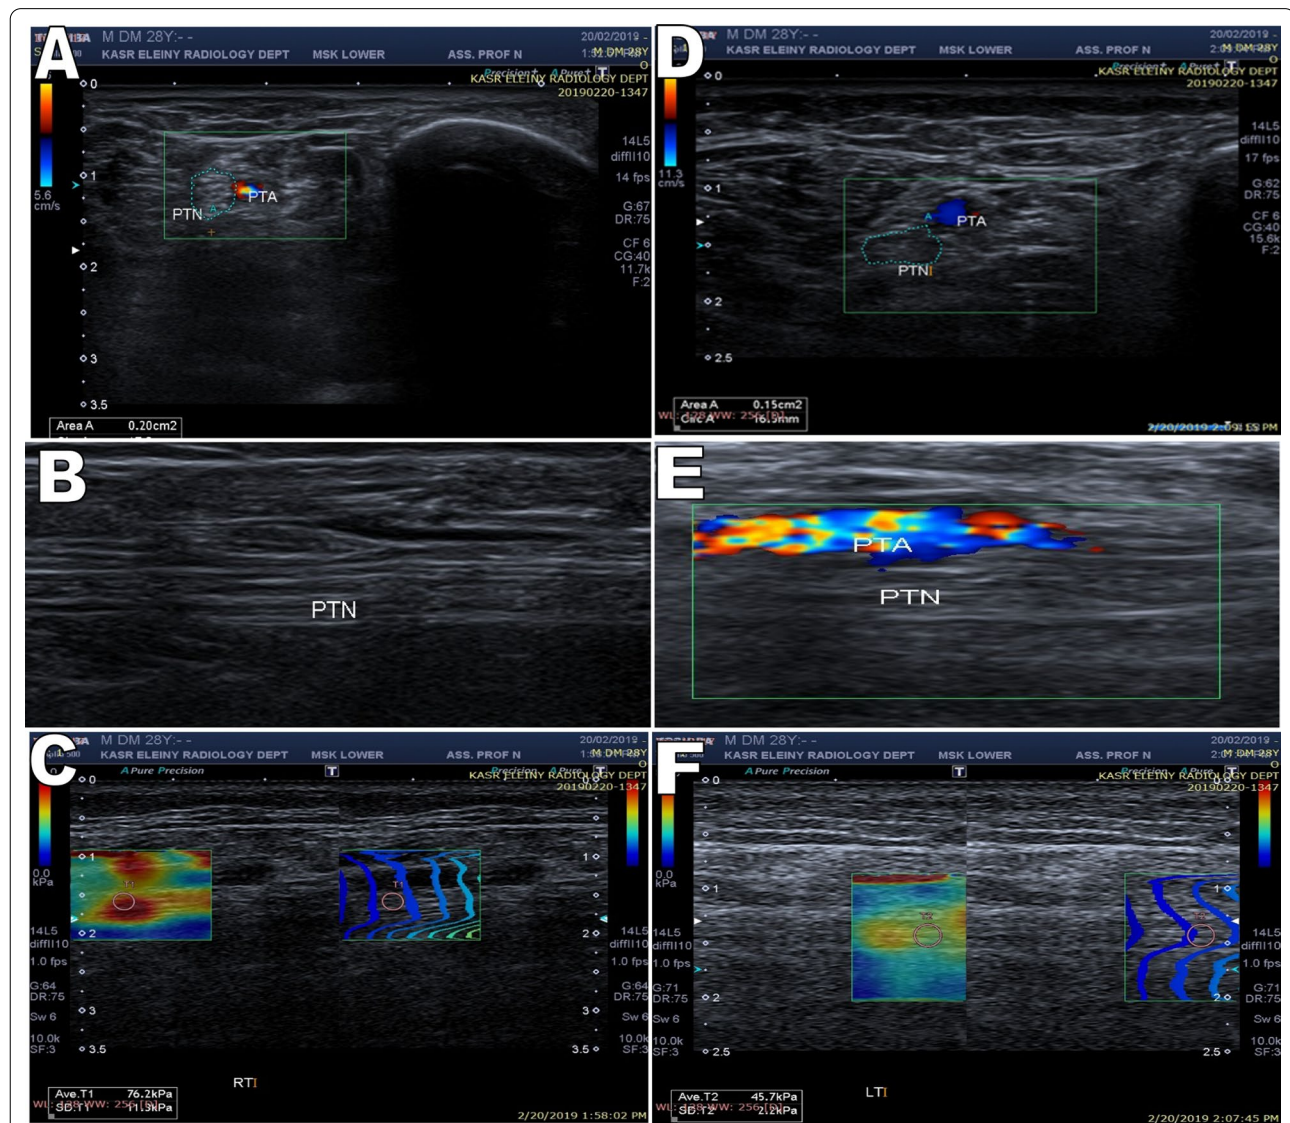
A 63-year-old male patient diabetic for 28 years on insulin treatment with uncontrolled blood sugar and elevated Hb A1c, presented with bilateral lower limb numbness, tingling, and burning sensation as well as axonal neuropathy on nerve conduction study. High-resolution ultrasound A shows the right PTN in relation to the PTA with its CSA measuring 20 mm². B B-mode image shows the longitudinal axis of the right PTN. C The right image is the B-mode, and the left image measures the elasticity of the PTN (76.2 kPa) with a color-coded box, circular ROI (T1) for quantitative measurements and a color code scale at the top side of the image. D demonstrates the left PTN in relation to the PTA with its CSA measuring 15 mm². E B-mode image shows the longitudinal axis of the left PTN. F The elasticity of the PTN (45.7 kPa) with a color-coded box, circular ROI (T2) for quantitative measurements, and a color code scale at the top side of the image. There is an increase in the CSA and stiffness of both posterior tibial nerves
